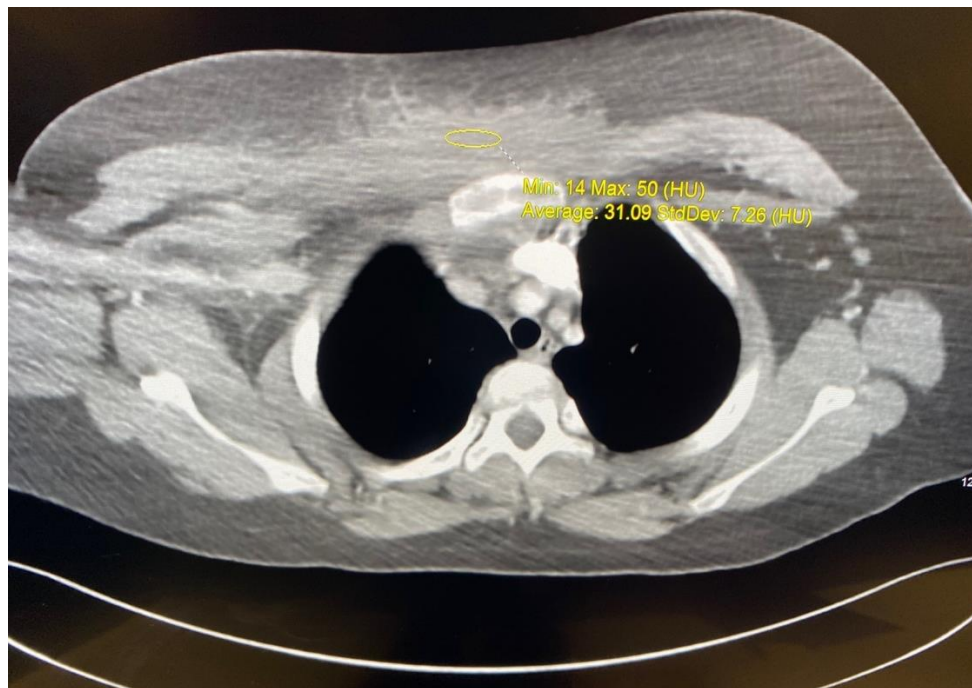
Transverse CT with contrast showing cellulitis/myositis in right chest wall.
